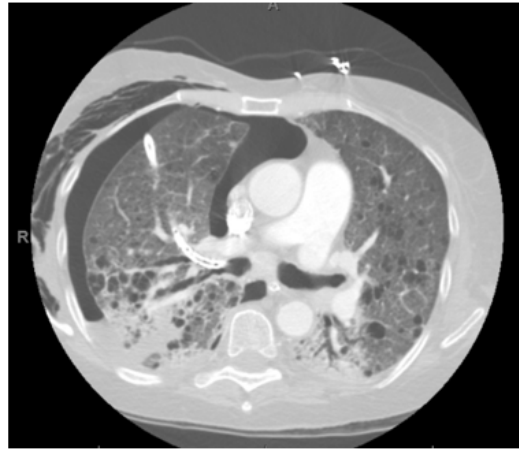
(Case 1): CT chest (transverse view) showing pigtail catheter in right main bronchus.
